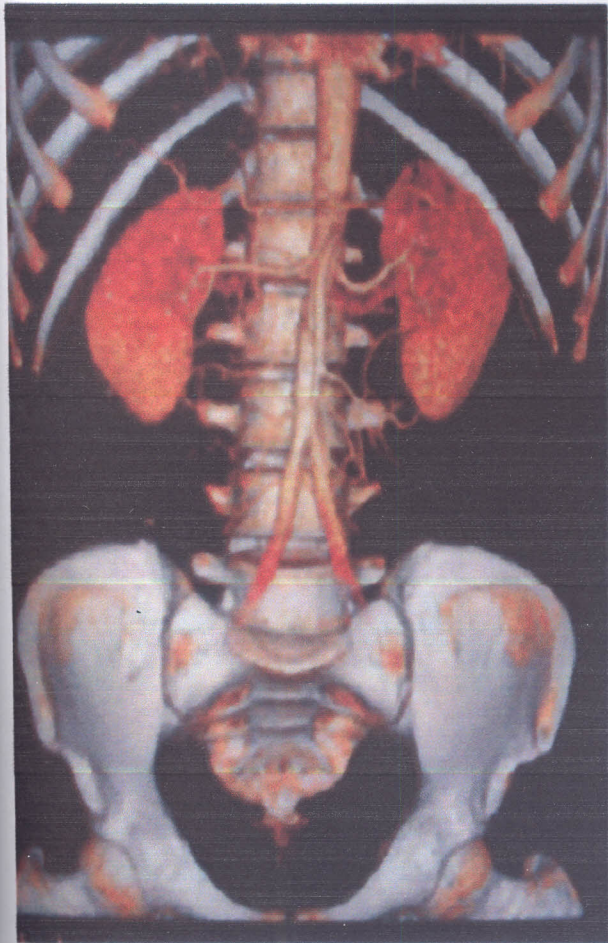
Volume rendering image of normal Renal CTA.
